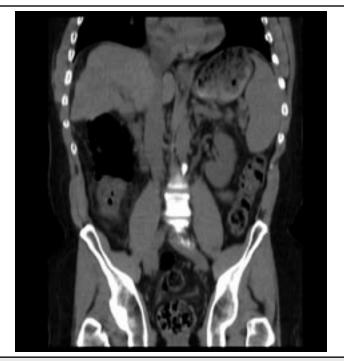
Sagital reconstruction on a non-contrast CT scan of the abdomen and pelvis demonstrating an intussuscepted segment of bowel.
